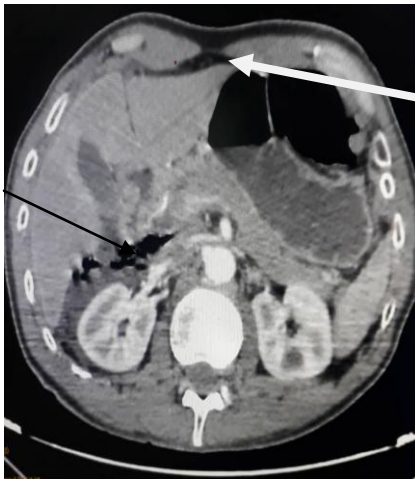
Abdominal CT scan image showing pneumoperitoneum and a peritoneal fluid effusion.
